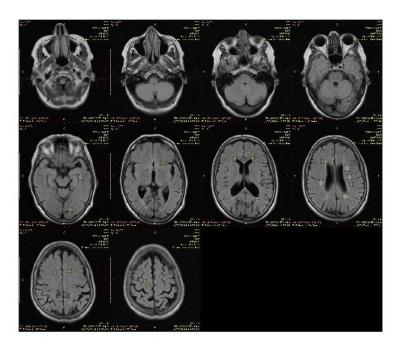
Lesion labeling example output. Patient 349, FLAIR scan. Pair slices only.
